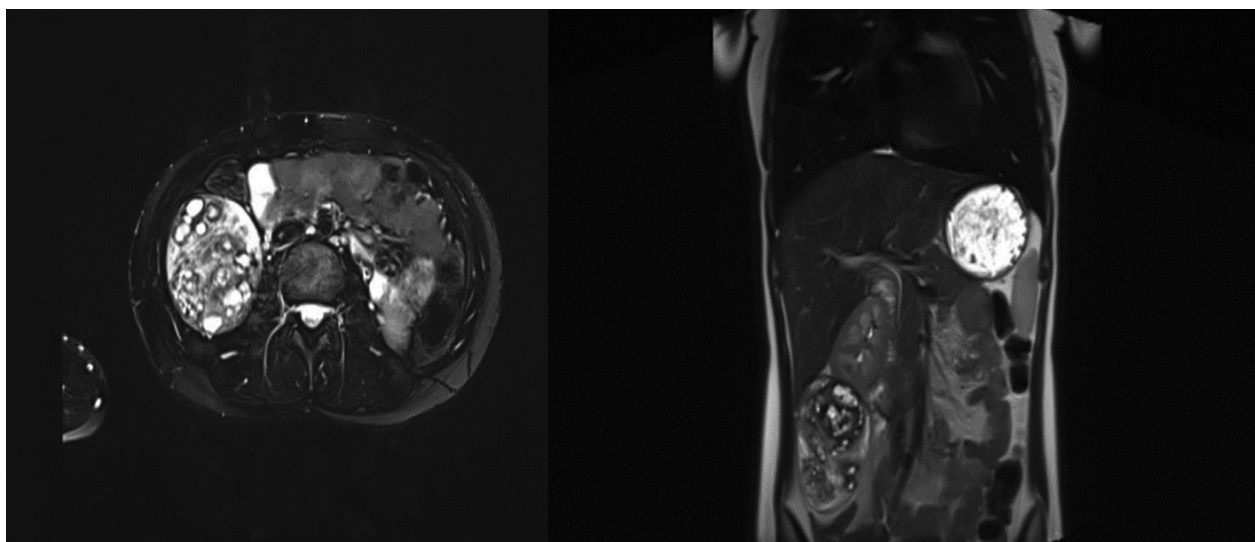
MRI scan image of a right renal tumor contrast retaining in transverse section and coronal section
